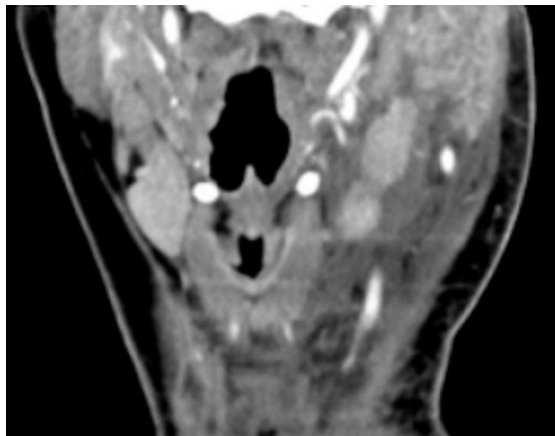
Coronal image from a contrast enhanced CT of the neck demonstrates diffuse asymmetric swelling of the left parotid gland with surrounding fat stranding without evidence of an obstructing stone, mass, or abscess. The acute periparotid inflammatory change is associated with thickening of the overlying platysma muscle, enlargement of adjacent lymph nodes, and extensive free fluid tracking throughout the left neck.
